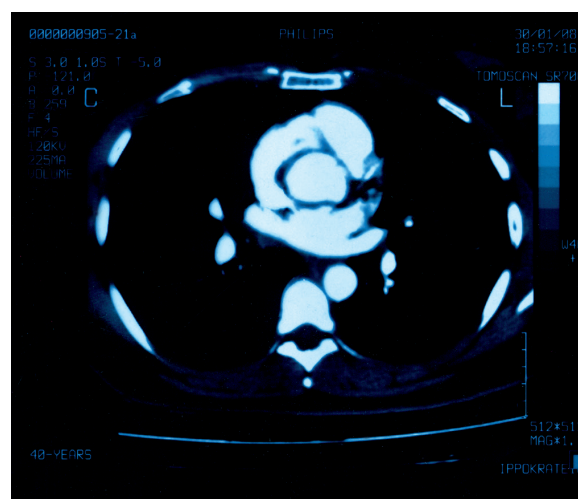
Spiral CT scan image showing normal lung vasculature.
